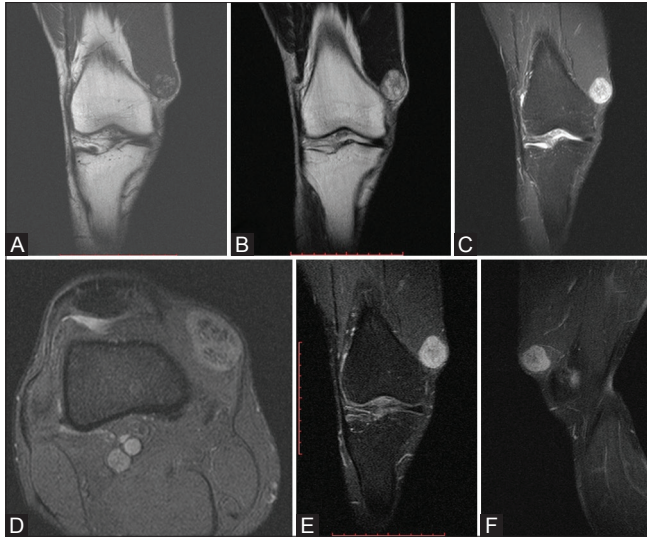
(A-F): MRI Coronal (A-C) T1W, T2W and STIR images showing well defined rounded lesion in vastus medialis muscle which is isointense on T1W with intralesional fat intensity (A), hyperintense on T2W and STIR (B and C) with T2 hypointense peripheral rim. The lesion shows fat suppression on the T2WFS image (D). Post-contrast coronal and sag (E and F) images showing avid heterogeneous enhancement
